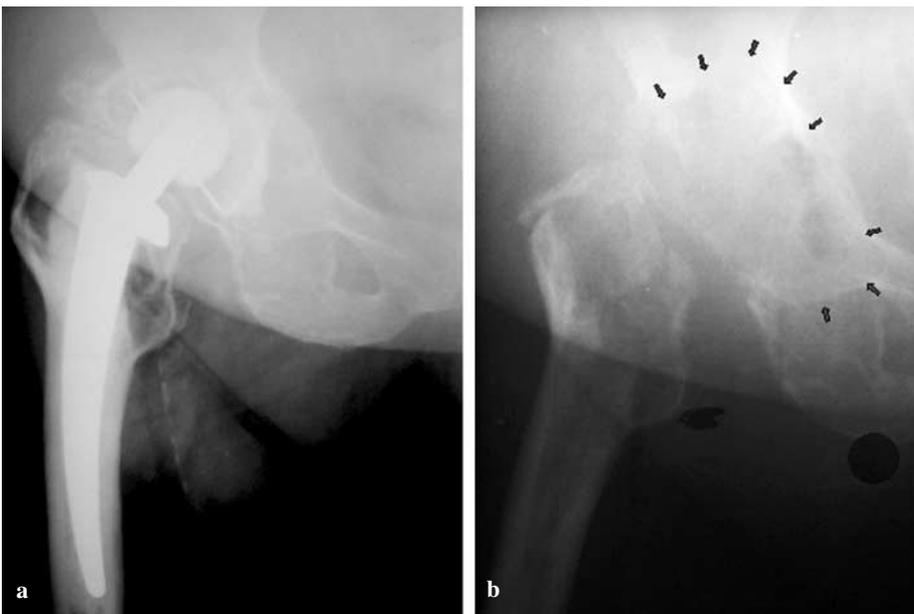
Radiographs of the right hip joint 11 years after arthroplasty. a There is implant loosening and acetabulum destruction. b After prosthesis removal, an acetabulum perforation of 4 cm diameter is visible. Arrows, extent of bone atrophy
